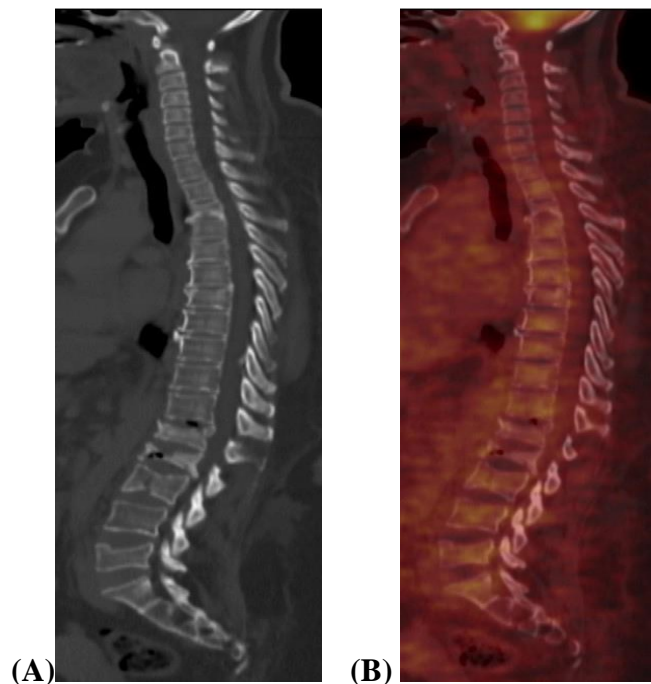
Sagittal CT(A) and fused 18F-FDG PET/CT (B) images of the vertebral column
